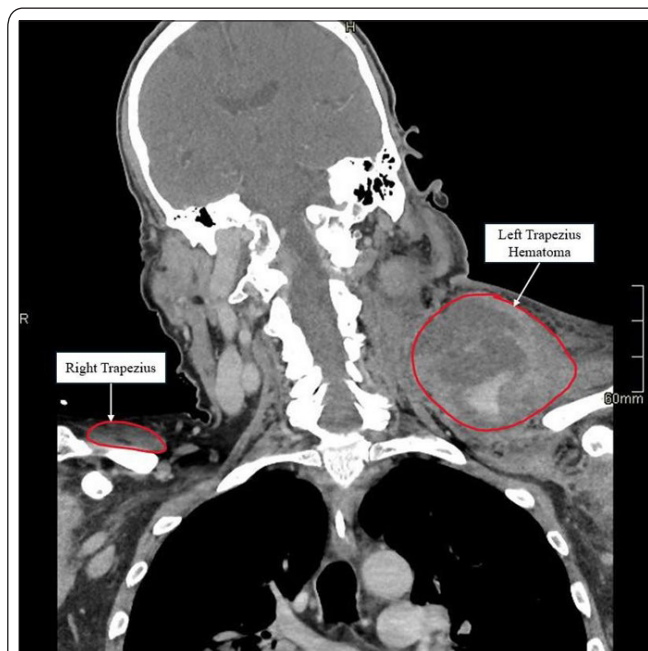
Computed tomography of the neck with contrast enhancement. Coronal slice demonstrating a large heterogenous collection measuring at least 6.7 × 9.2 × 7.5 cm arising from the left trapezius muscle. There is significant enlargement of the trapezius muscle and a layering high density within the collection, in keeping with an active bleed.
